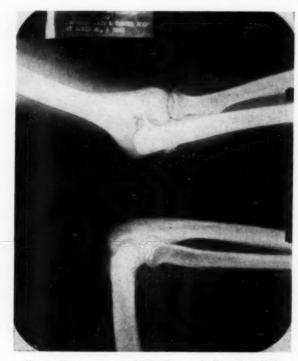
Roentgenogram of left elbow made December, 1949.
